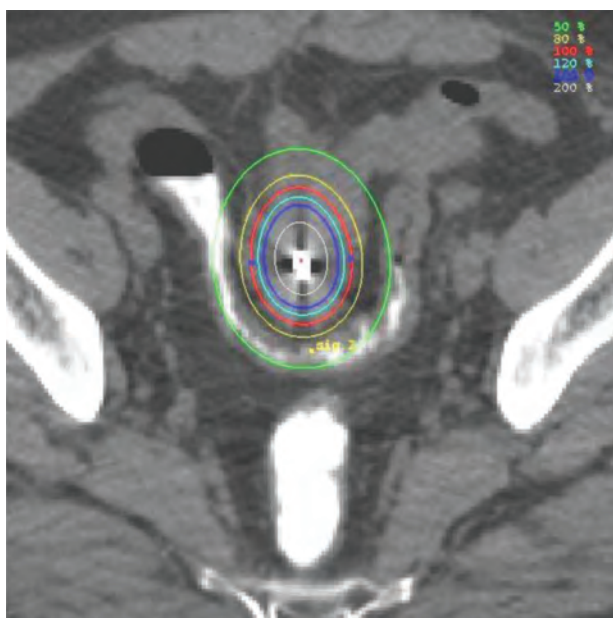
Axial CT slice showing a contrast-filled loop of sigmoid in close proximity to the high-absorbed-dose-volume from the intrauterine applicator, necessitating a change in loading pattern.
